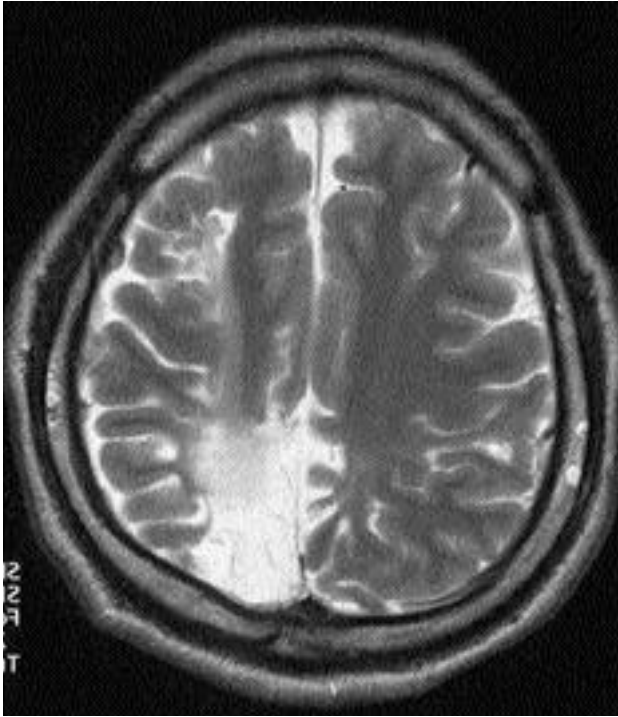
MRI image of the patient with involvement of optic cortex
